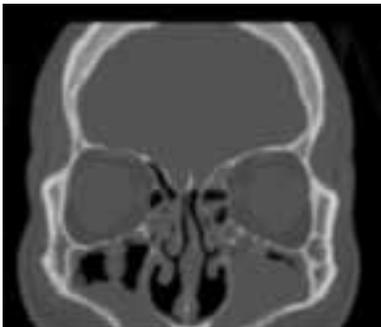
Pre-op CT scan of the sinuses showing CRS with opacification/disease in the maxillary and ethmoid sinuses.
